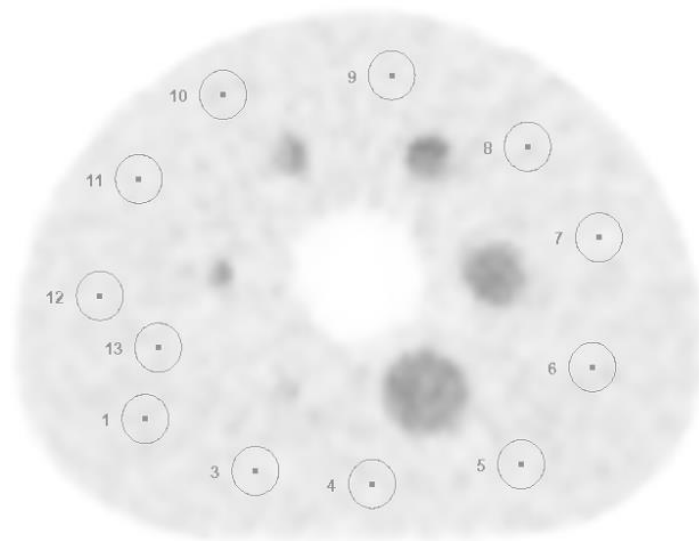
14 ROI selected to SUV mean, SUV max, max and average concentration in bcg.
